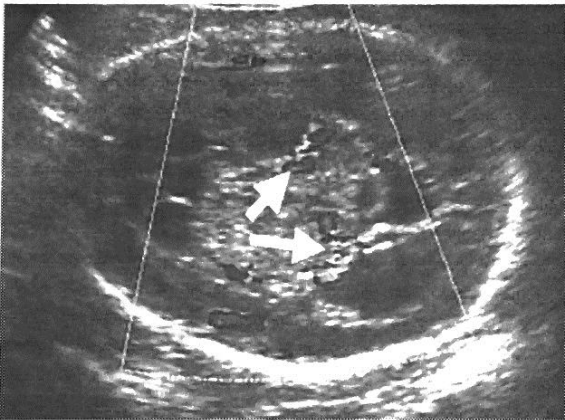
Doppler imaging demonstrating vascularity within the intracranial mass (arrows).
